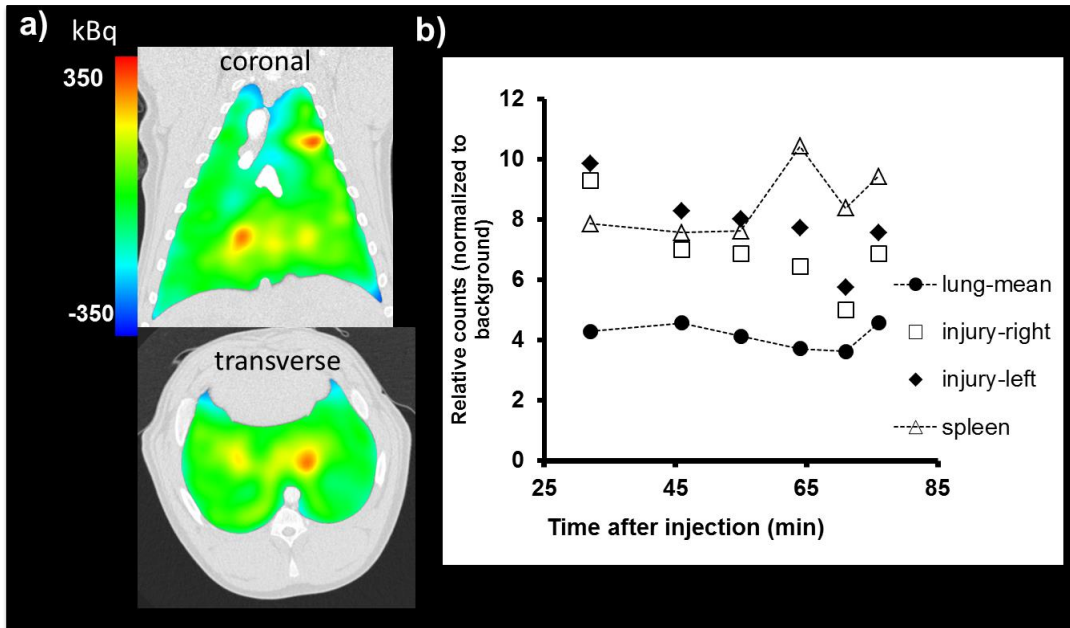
(a) coronal and transverse views of SPECT images co-registered to MDCT images, showing regional hot spots in the apical and basal lung where gastric acid was instilled in the airway (b) WBC kinetics, after correcting for ^{99m}Tc decay, showing gradual loss of counts in the inflamed regions and increase in counts in the spleen.
